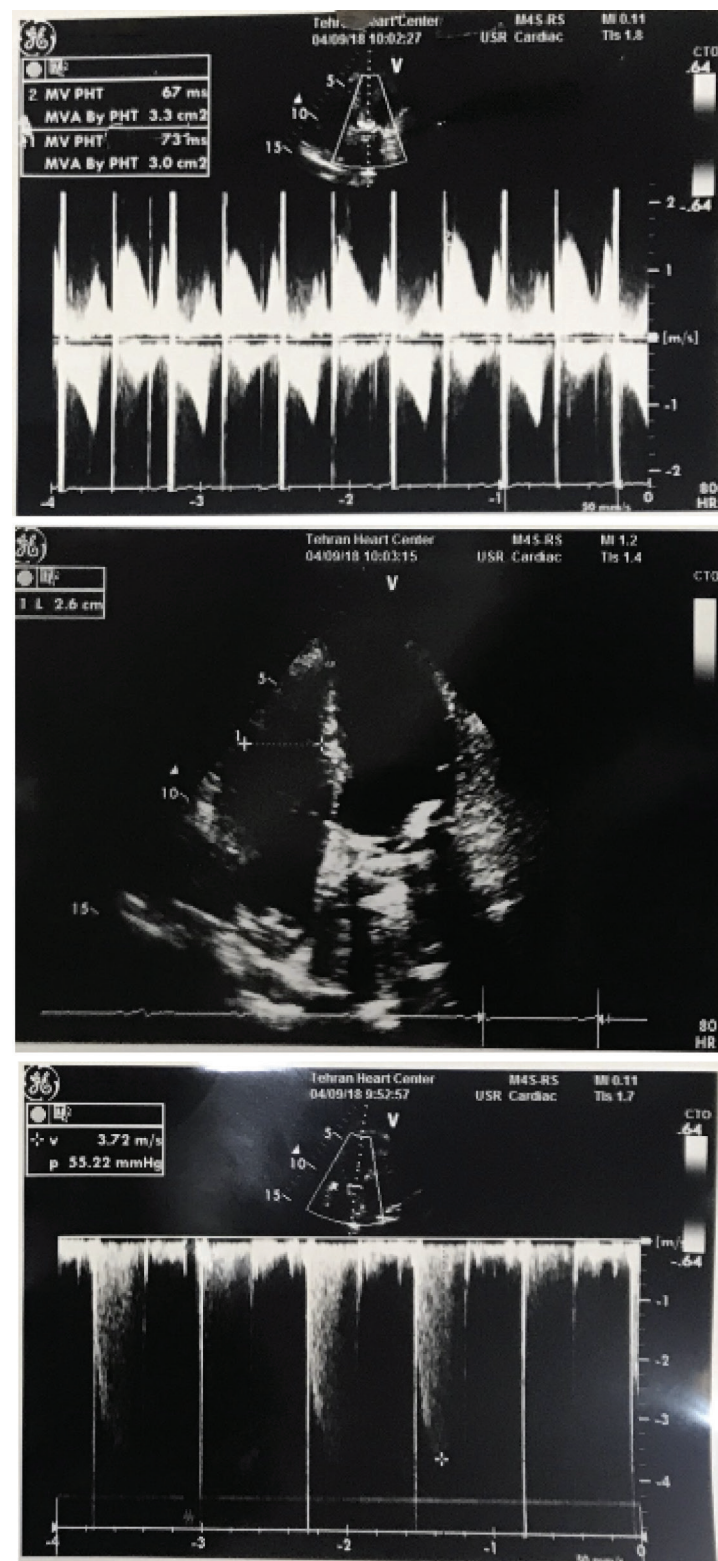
Echocardiography after mitral valve replacement with a St. Jude Medical Regent aortic prosthesis. Upper figure: mitral flow showing a mitral valve area (PHT) of 3.0 cm², mean gradient of 3.5 mmHg and maximum gradient of 7 mmHg. Middle figure: Two-dimensional echocardiography showing the mechanical prosthesis in the mitral position. Lower figure: tricuspid reflux with a pulmonary artery pressure of 55 mmHg.
